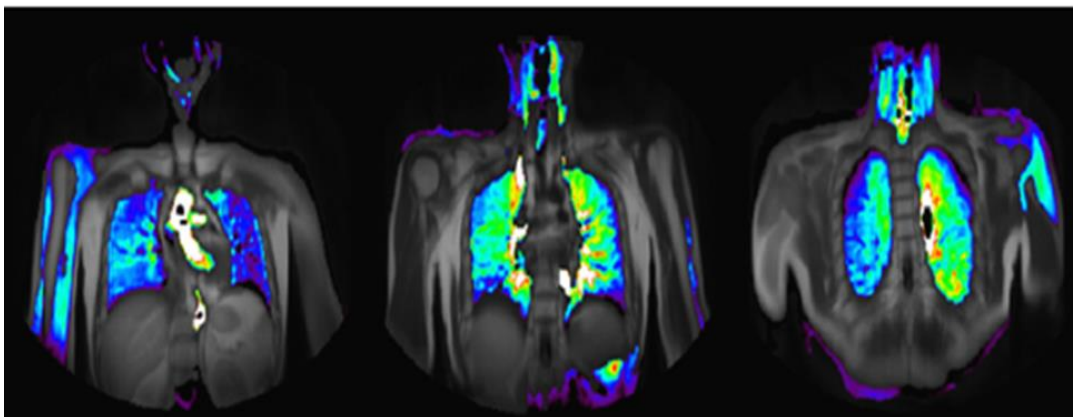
The map of the OE-MRI shows a healthy, 58-year-old male volunteer, whose lungs are both homogenous with a high signal of oxygen enhancement (from left to right) (Ohno and Hatabu, 2007).
